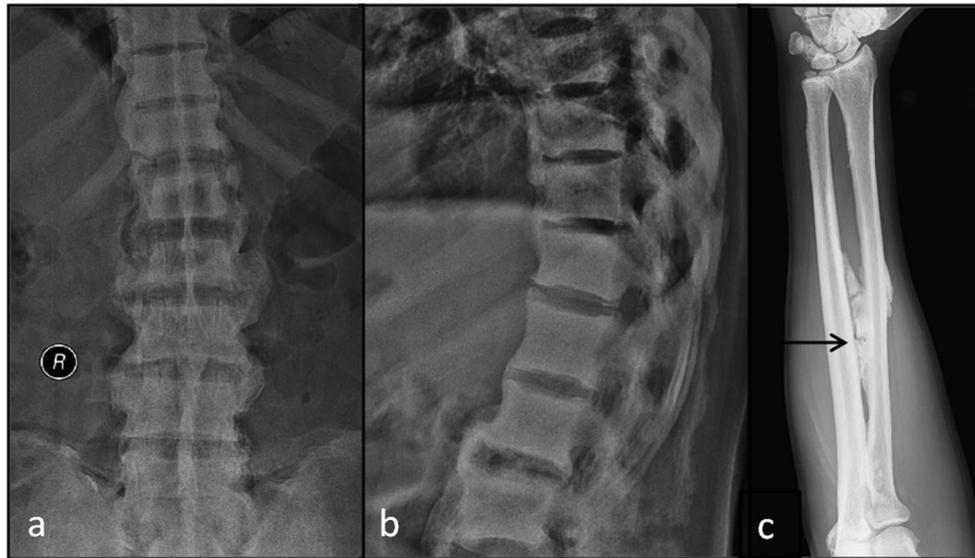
Pre-operative radiograph of thoracolumbar spine a, b showing a break in the anterior syndesmophyte at T12–L1 and c forearm with interosseous calcification marked by a *black arrow*
